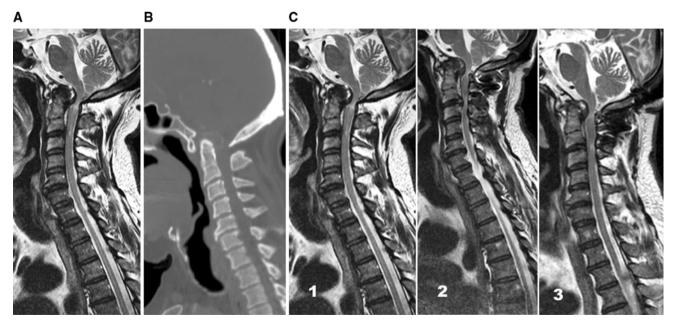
Patient 4: a sagittal, T2-weighted MRI demonstrating a retroodontoid pseudotumor, with patchy signal alteration, compressing the spinal cord. Such appearance is also seen on sagittal CT scan (b), which also shows an eggshell calcification of the pseudotumor.
